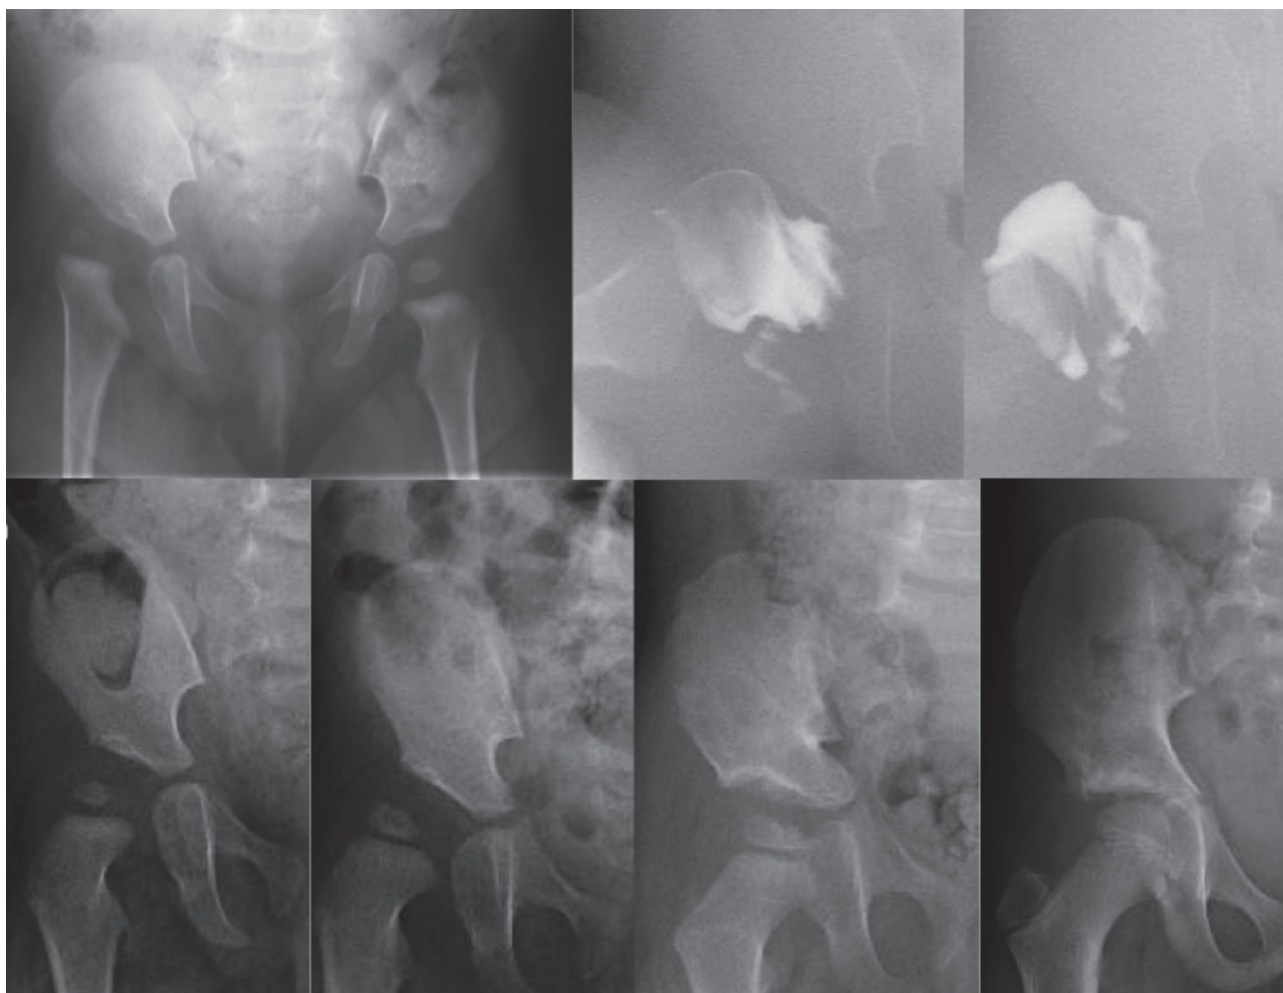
Example of a closed reduction with further need of additional surgery. 1A-B. 7-month-old girl with right Tonnis-grade2 hip dislocation. After 8-day-overhead traction, a closed reduction was attempted. 1C. Reduction was scored grade 1. 1D: radiograph at the age of 12 months. 1E: radiograph at the age of 19 months. A Salter innominate osteotomy was performed at the age of 21 months. 1F: radiograph at the age of 2 years and 6 months. 1G: radiograph at the age of 6 years and 6 months.
